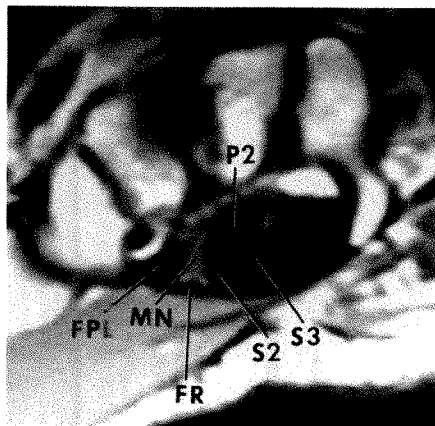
MR image (600/20) of wrist in 45° flexion shows volar shift of flexor tendons in comparison with neutral and especially extension images. Median nerve is interposed between flexor pollicis longus and sublimis 2. Appearance is similar to neutral interposed position of Fig. 2 except for volar tendon arrangement in flexion. (See key for abbreviations.)
